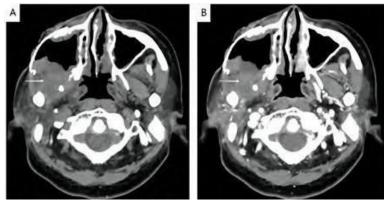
A: Plain CT scan and transverse view of head and neck: small pieces of very low-density adipose tissue could be filled in the surgical area of right masticator space, and the CT value was about –95 HU, with uneven density. On the posterolateral side of the right maxillary sinus and medial side of the titanium mesh, strip-like slightly low-density shadows could be observed, with a CT value of about 52 HU, and the boundary was unclear (white arrow). B: Contrast-enhanced CT and transverse view: the lesions at the posterolateral side of the right maxillary sinus and the medial side of the titanium mesh had an obviously strip-like enhancement, the CT value was about 85 HU, and the boundary was unclear (white arrow).
